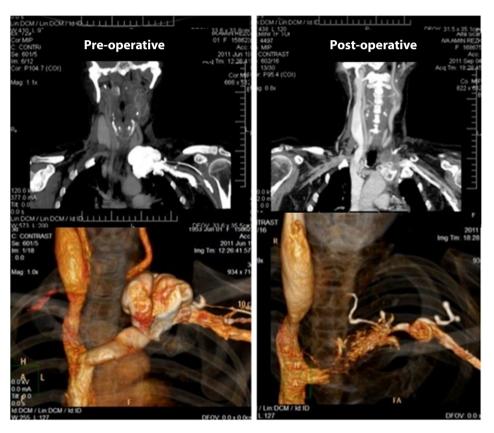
Contrast enhanced CT study (venous phase) with coronal and reconstructed pre- and post-operative images. Pre-operatively: aneurysmally dilated venous sac connected to the left subclavian vein. The left internal jugular vein is not visualized whilst the right is significantly dilated; post-operatively: total thrombosis of the aneurysm with apparent attenuation of the left subclavian vein in the coronal plane.
